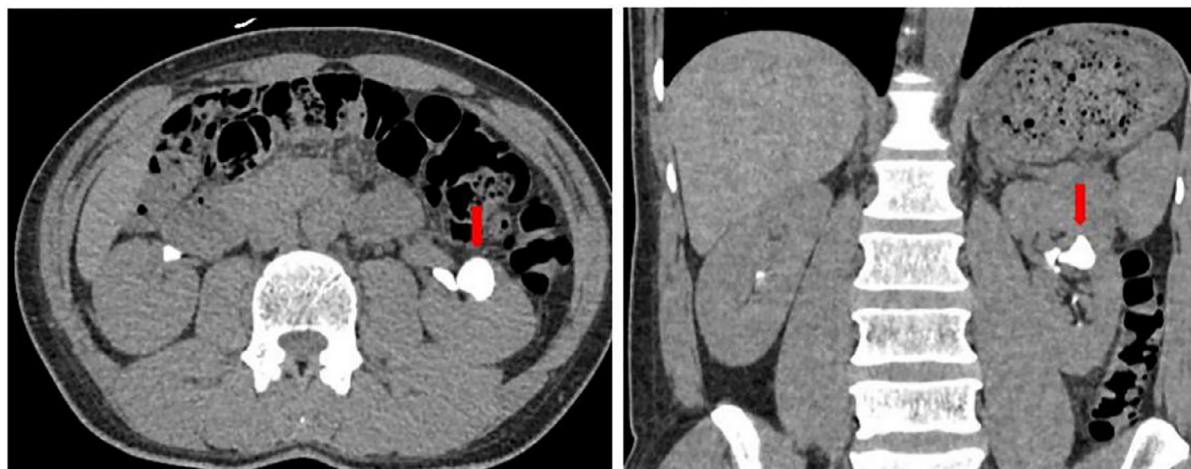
CT Urography (axial and coronal reformatted) 6 hour delayed images showing retention of contrast medium in the focally dilated minor calyx which communicates with the renal pelvis in keeping with a hydrocalyx.
